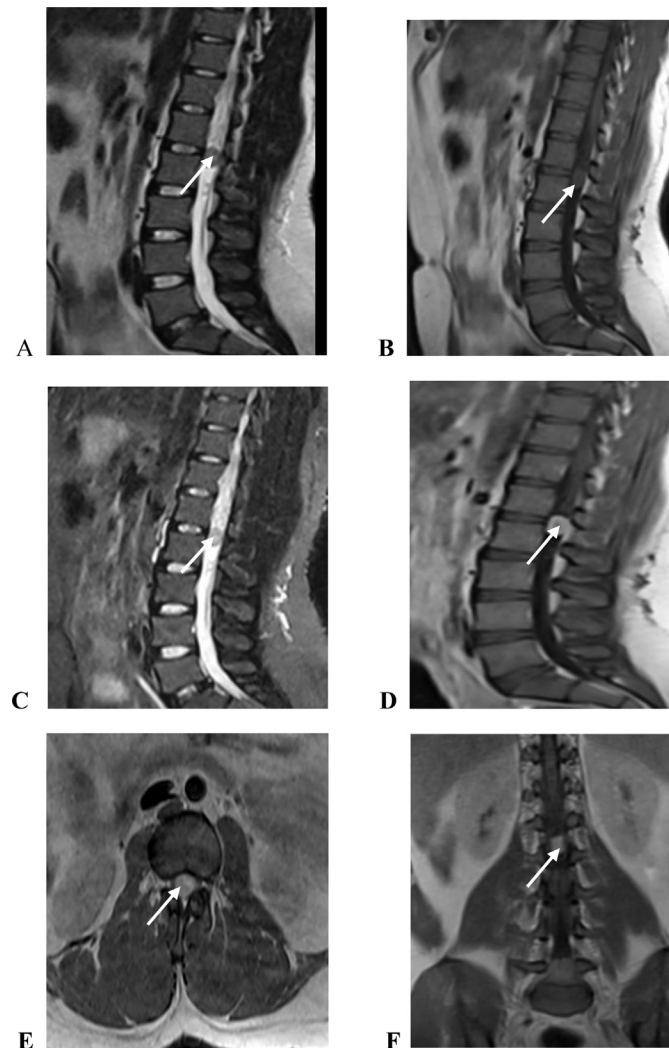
Case 1. Twenty five-year-old male with spinal cord tuberculoma. The multiplanar spinal MRI (thoracolumbar) shows an intrathecal, extramedullary lesion measuring 16 × 12 mm at the L2 level. The lesion is isointense on T1W (arrow, B), iso to hypointense on T2W (arrow, A) and STIR (arrow, C) with a small focus of central hyperintensity on these sequences. On postgadolinium imaging, the lesion demonstrates primarily peripheral enhancement (arrows, D, E, F) which favors a differential of spinal TB caseation stage.
